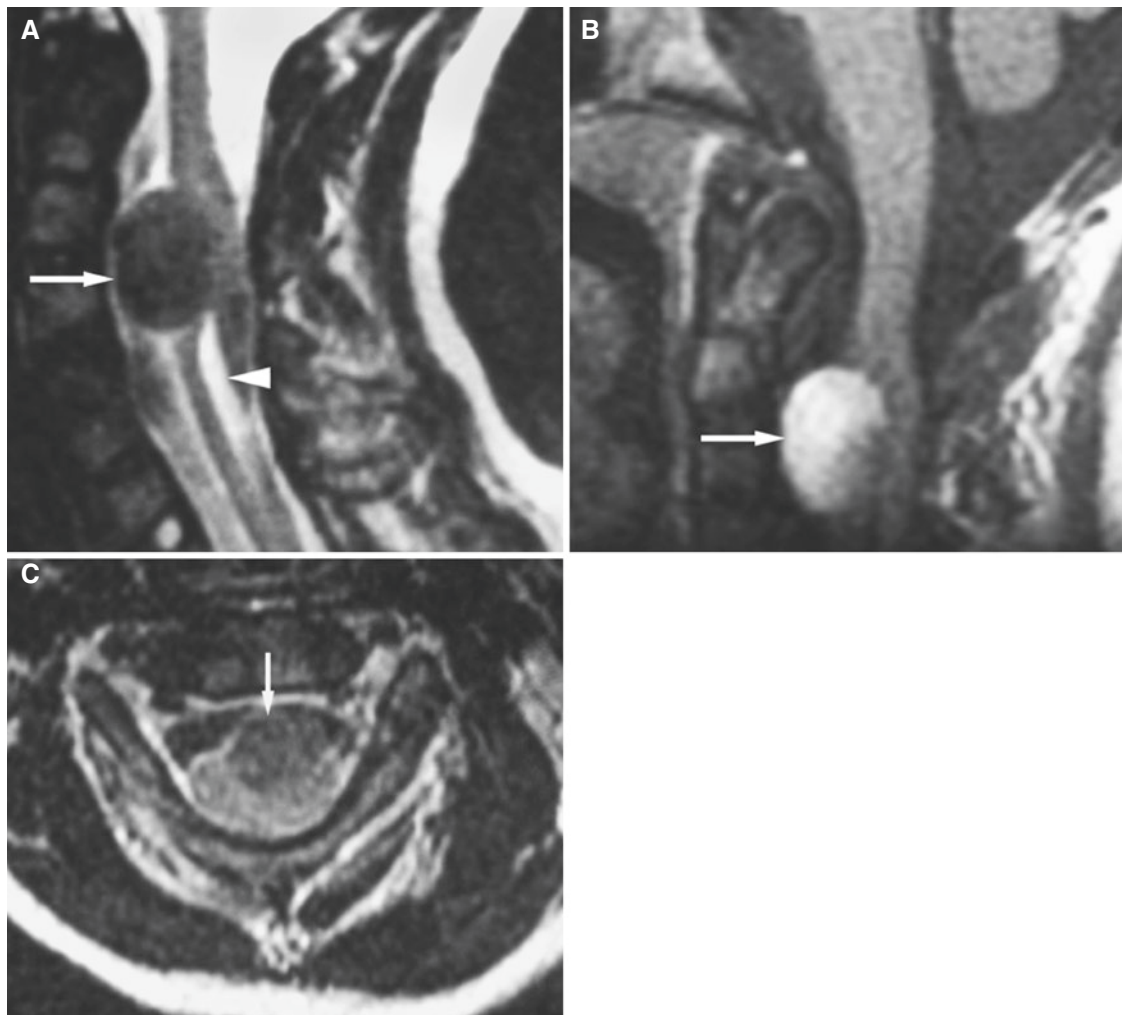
Spinal teratoma; 7-year-old female with right hemiparesis. (A) Sagittal T2-weighted MRI shows enlargement of upper cervical canal. Anterior to cord, there is hypointense mass displacing cord (arrow). Exophytic mass largely fills spinal canal with almost complete obliteration of CSF space. Only posterior margin appears to infiltrate
